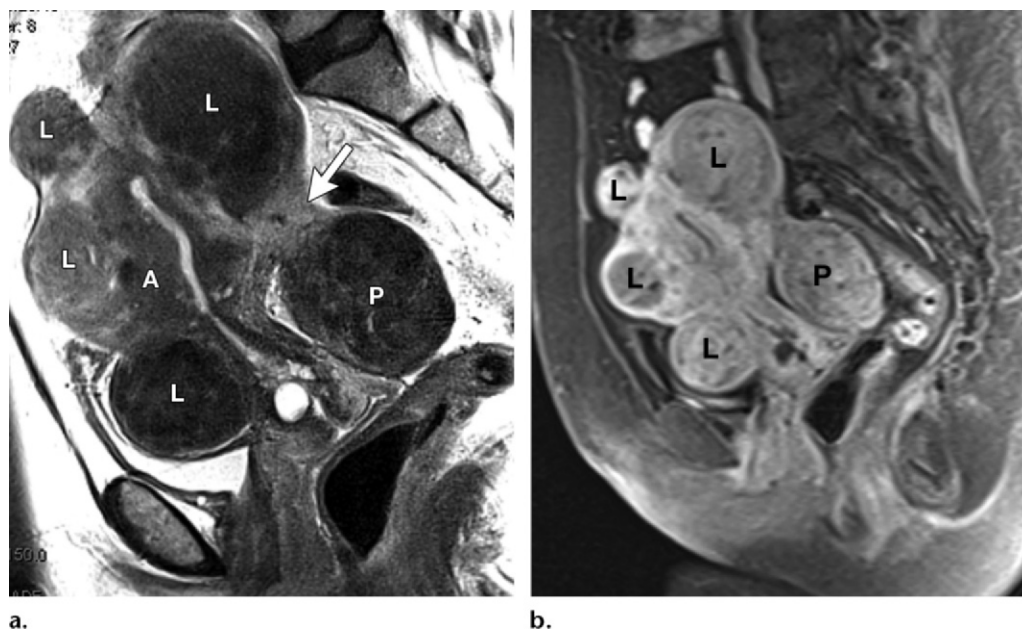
Coexistence of adenomyosis and leiomyomas. Sagittal T2-weighted (a) and contrast-enhanced fat-suppressed T1-weighted GRE (b) images show a uterus containing adenomyosis (*A* in a) and multiple leiomyomas (*L*). At least one of the leiomyomas is pedunculated (*P*) with a short narrow stalk (arrow in a). (Case courtesy of Susan M. Ascher, MD, Georgetown University Hospital, Washington, DC.)
